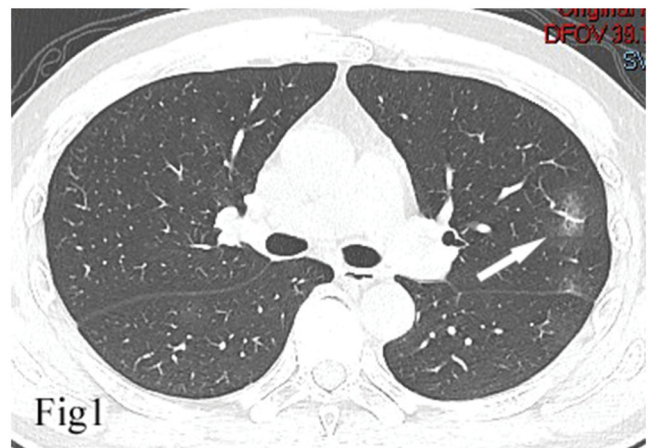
A 39 year old male patient diagnosed with mild COVID-19, with a chief complaint of “febrile for two days”. The CT showed a focal GGO with a central thickening of airway wall (white arrow), which we named as dandelion sign.
